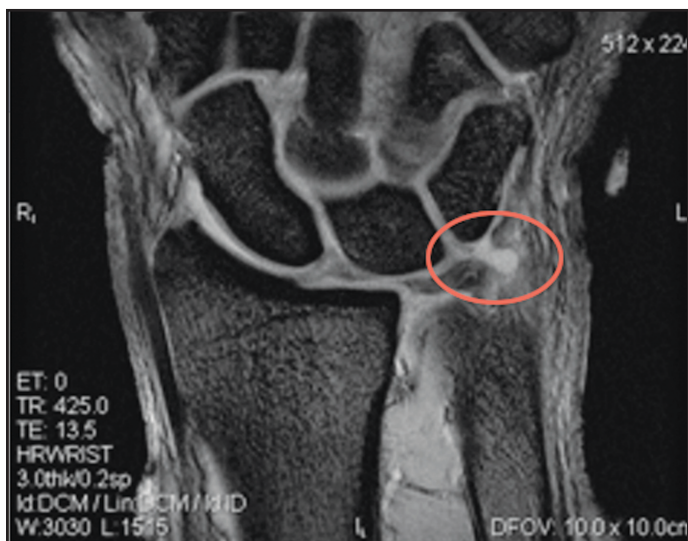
MRI image demonstrating visualization of the triangular fibrocartilage complex, as noted in the colored oval.
